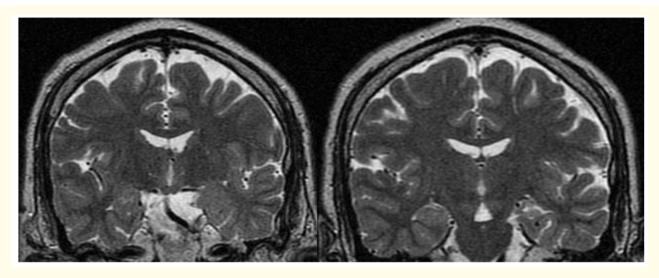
MRI of brain imaging study showed left mesial temporal sclerosis.
